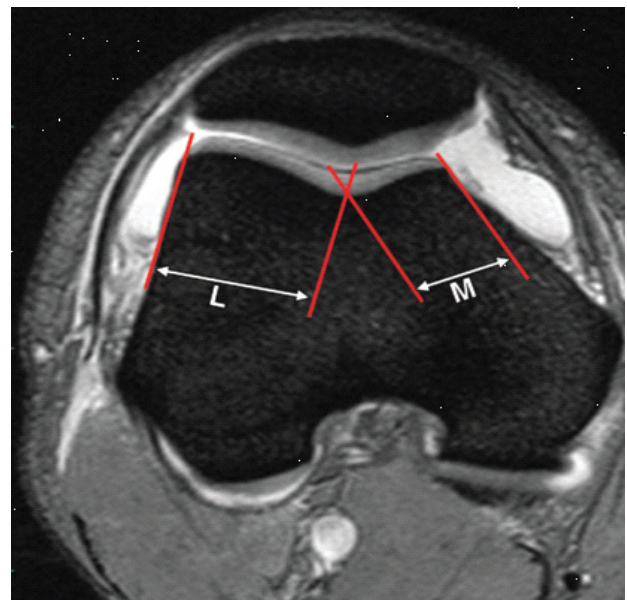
Trochlear facet asymmetry assessed on axial fat-saturated T2-weighted MR images. Asymmetry of the medial facet length (M) and the lateral facet length (L) is calculated as the ratio of the medial facet length divided by the lateral facet length expressed as a percentage ($M/L \times 100\%$). A trochlear facet ratio of less than 40% indicates dysplasia.
